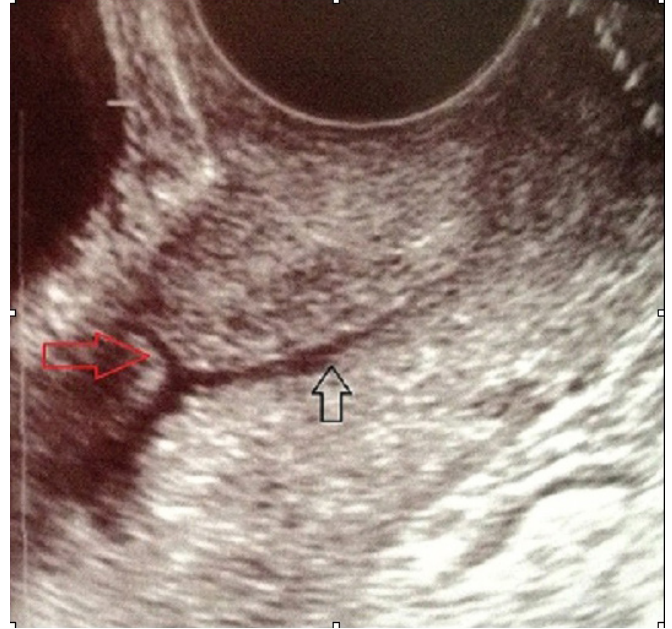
Transvaginal ultrasonography; normal uterin anatomy was received 103 days after spontan resolution of ectopic scar pregnancy. Red arrow shows scar line. Black arrow shows cervical canal.
